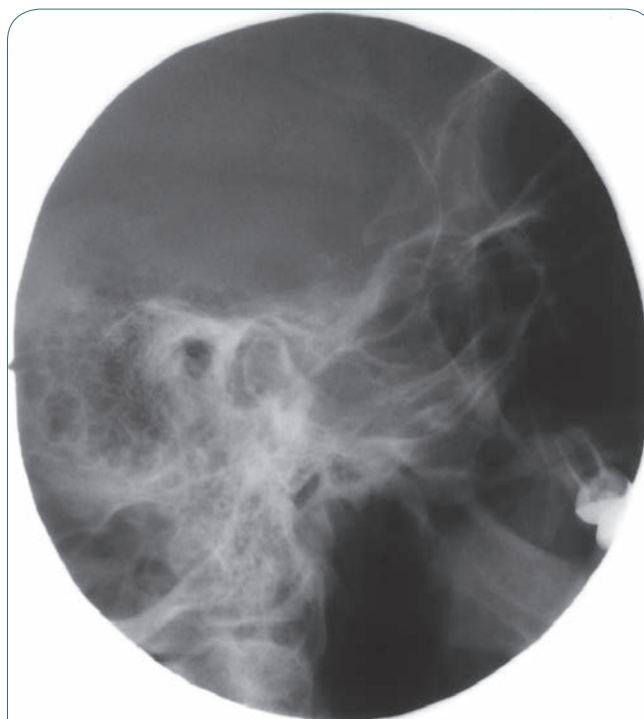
Transcranial TMJ radiograph with the mouth closed, showing the relationship of the condyle to the glenoid fossa.
